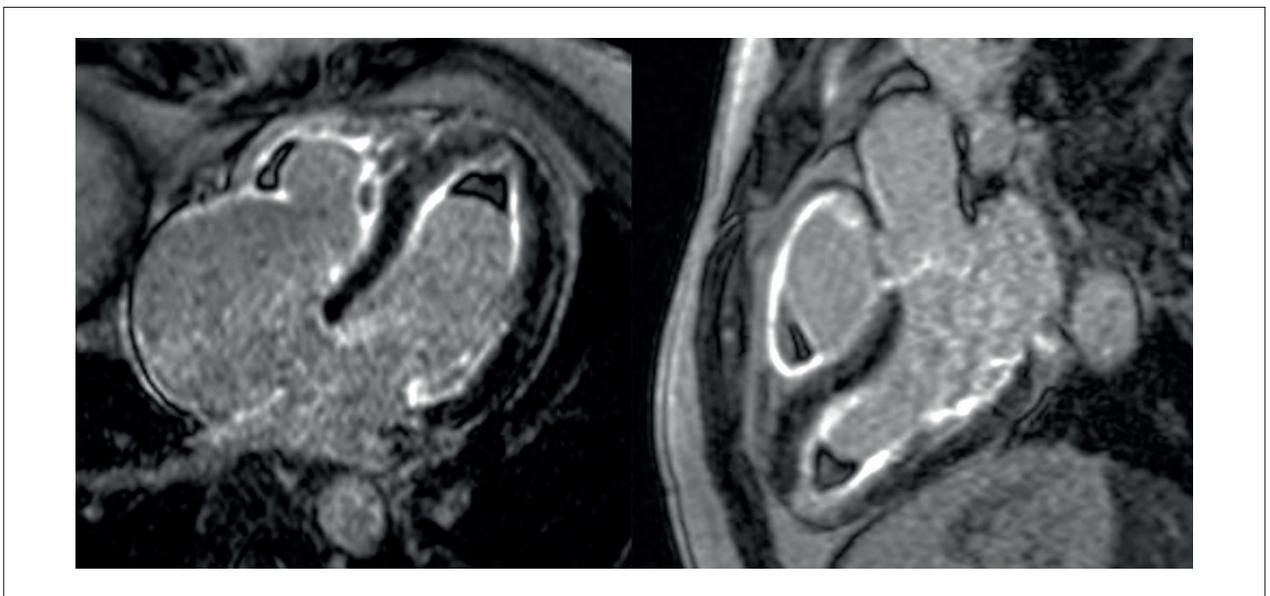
Male patient, 33 years old, with endomyocardial fibrosis with biventricular involvement and important dilation of the right atrium. Delayed-enhancement MRI showed diffuse biventricular subendocardial involvement, corresponding to fibrosis. Note images with hypointense compatible with small cavitary thrombi, in both ventricles, the largest at the apex of the left ventricle measuring 9 × 11 mm.
